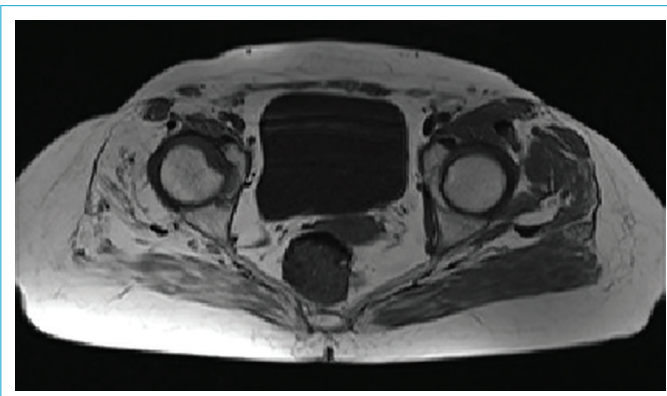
Axial T1-weighted image demonstrating right hip dysplasia and increased femoral head anteversion in a 29-year-old female patient.
